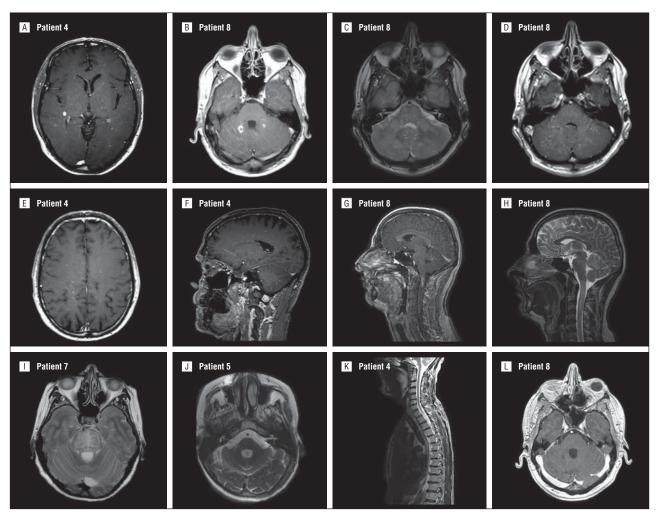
Relevant magnetic resonance imaging in 12 patients having chronic lymphocytic inflammation with pontine perivascular enhancement responsive to corticosteroids using gadolinium-enhanced T1-weighted and T2-weighted imaging. Gadolinium-enhanced T1-weighted images show a homogeneous gadolinium-enhancing lesion greater than 3 mm (A) and a gadolinium-enhancing pattern as a closed ring (B). Increased T2-weighted signal is confluent (C) and exceeds the size of the corresponding punctuate gadolinium-enhancing lesions (D). Axial (E) and sagittal (F) gadolinium-enhanced T1-weighted images show juxtacortical lesions. Gadolinium-enhanced T1-weighted (G) and T2-weighted (H) images show a large confluent spinal cord lesion. Pons swelling (I), brainstem atrophy (J), spinal cord atrophy (K), and black hole (L) are shown.
